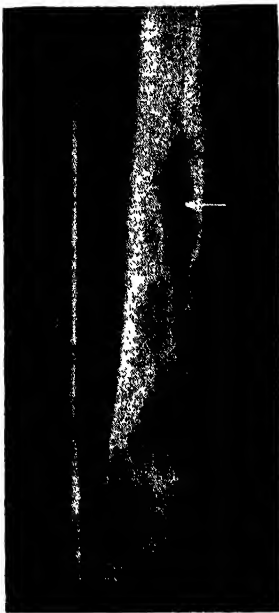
Radiograph in a case of osteomyelitis showing much new bone formation and a sequestrum (marked by arrow).
